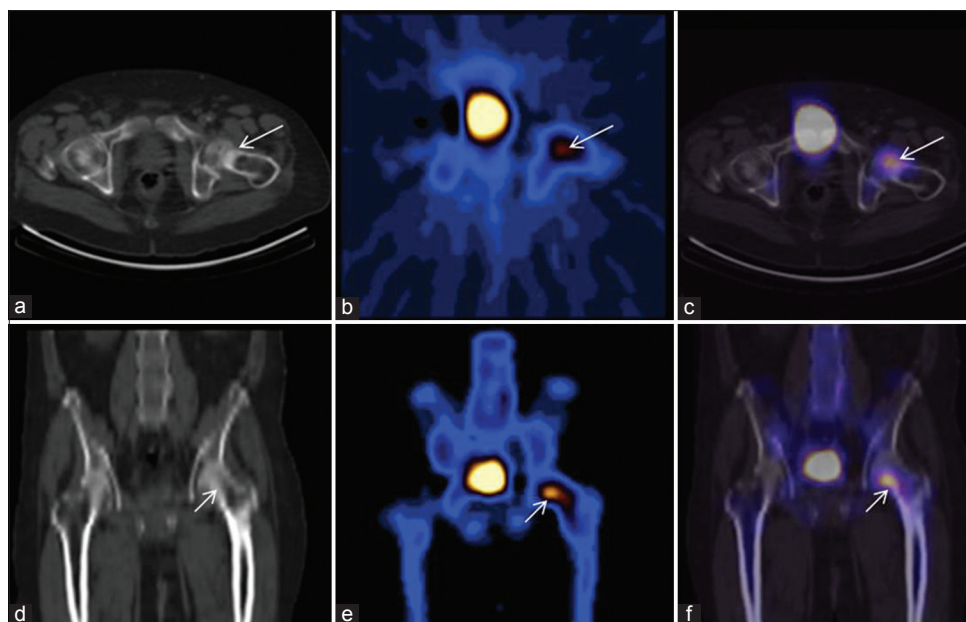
Computed tomography, single photon emission computed tomography, and fused single photon emission computed tomography/computed tomography images in axial (a-c) and coronal (d-f) views accurately localize the abnormal tracer uptake to the left femoral inferior neck (arrows), with sclerosis seen on corresponding computed tomography image
